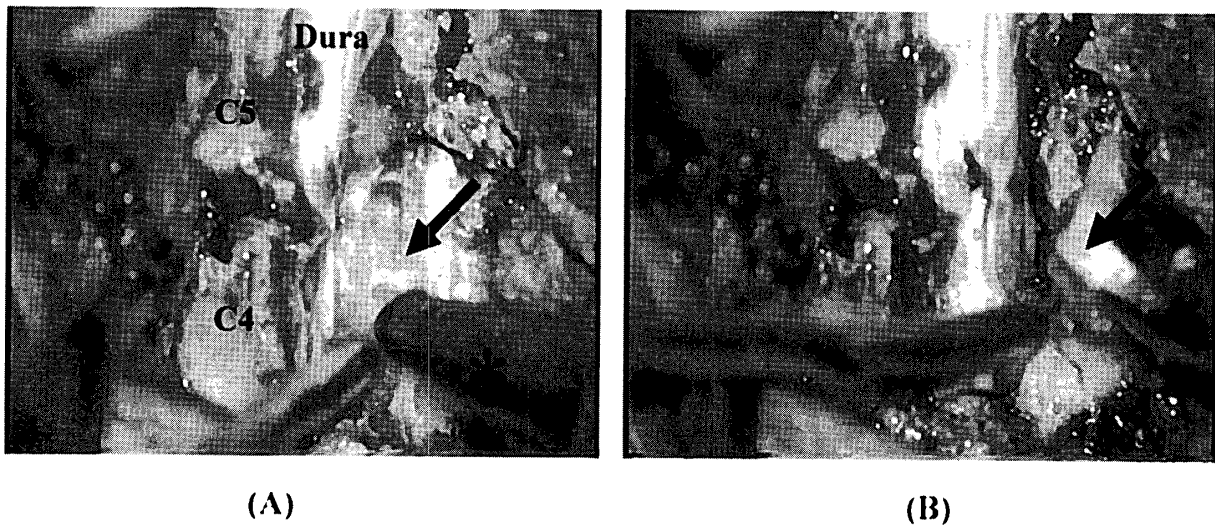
Operative view. A: Spinal cord is compressed by the ossified ligament (arrow) located at C4-C5 level, and the calcification was removed by ultrasonic bone curette (\*). B: The ossified ligament (arrow) was removed, and the dura recovered to the normal size.
